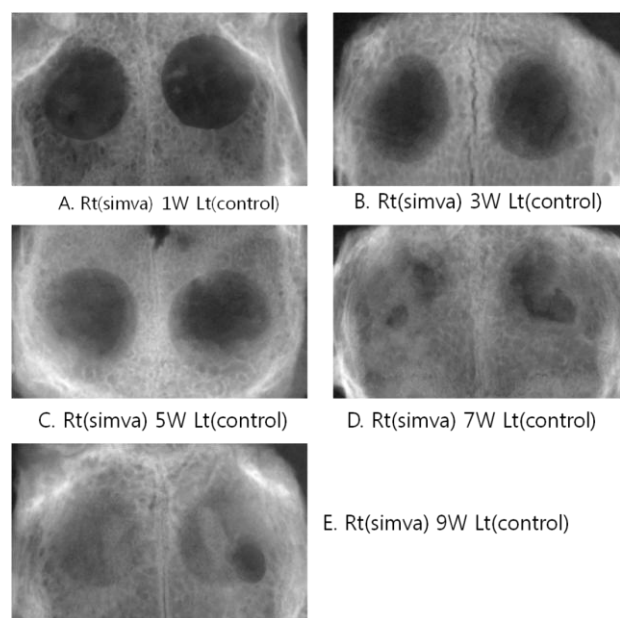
Soft x-ray radiographies at 1 week (A), 3 weeks (B), 5 weeks (C), 7 weeks (D), and 9 weeks (E) after implantation
